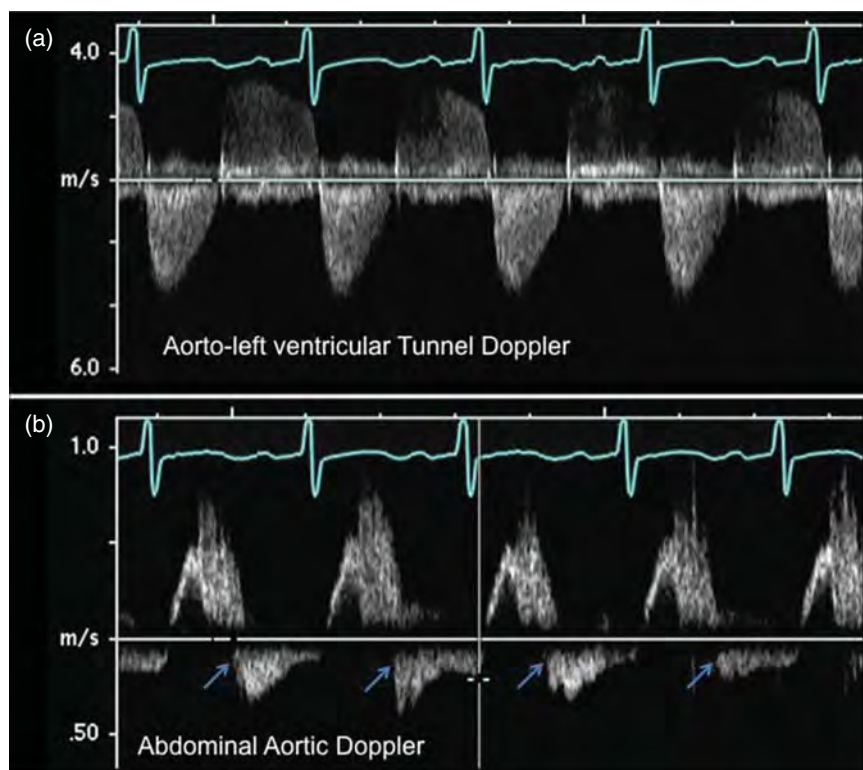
A Doppler evaluation of a neonate with an aorto-left ventricular tunnel (AoLVT). (a) A continuous wave Doppler tracing of the flow through the AoLVT itself. The diastolic signal (above the baseline) represents the “regurgitant” flow traveling from the aorta, through the tunnel, and into the left ventricle. The systolic ejection signal (below the baseline) has an increased maximum velocity, consistent with a moderate pressure gradient between the ventricle and the aorta due to “stenosis” of both the aortic valve and the AoLVT (type 3). (b) The lower image shows the pulsed wave Doppler signal taken from the patient’s abdominal aorta. In addition to normal systolic forward flow (above the baseline), there is also prominent, holodiastolic reversal of flow (arrows). This reversed flow is secondary to the large diastolic flow through the AoLVT into the ventricle and is indistinguishable from the pattern created by severe aortic valve regurgitation.
